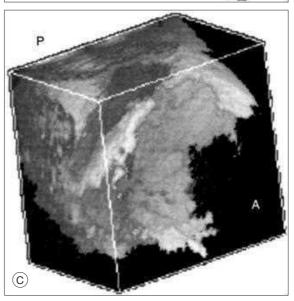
A Three-Dimensional Ultrasonogram of Choroidal Hemorrhage. A_i Anterior; P_i posterior.
